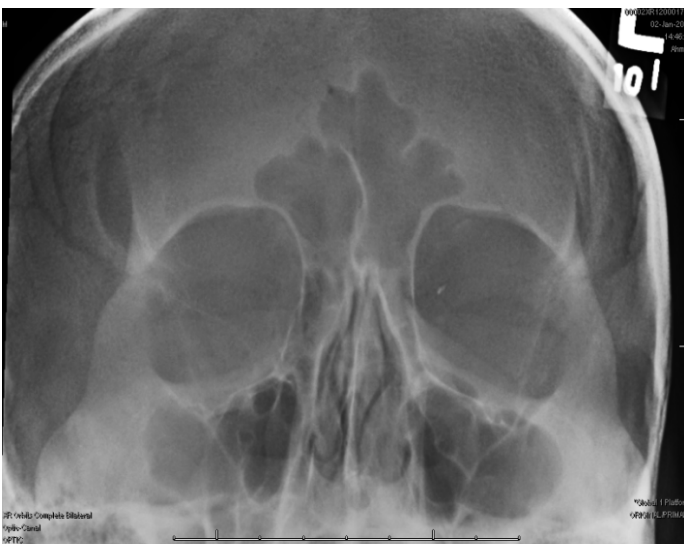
Plain X-RAY of the orbits. Note the very small, 1.8 mm radiopaque shadow in the left orbital region, representing a metallic foreign body.
